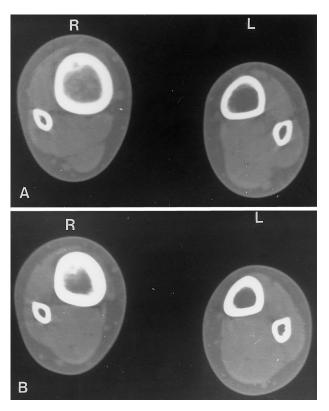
CT sections 2.5 cm apart show the multicentric topography of the lesion and reveal a ring-like structure consistent with the "nidus" of an osteoid osteoma
